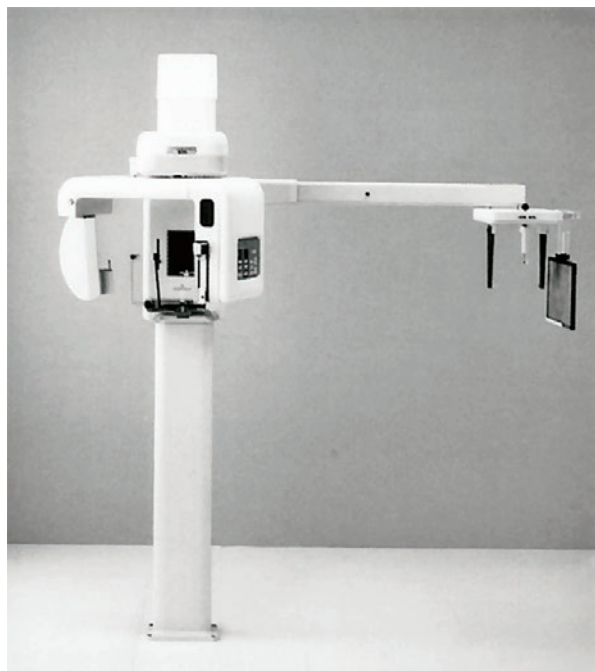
Example of a combined orthopantomogram imaging device and a cephalogram for film-based or phosphor-plate imaging
